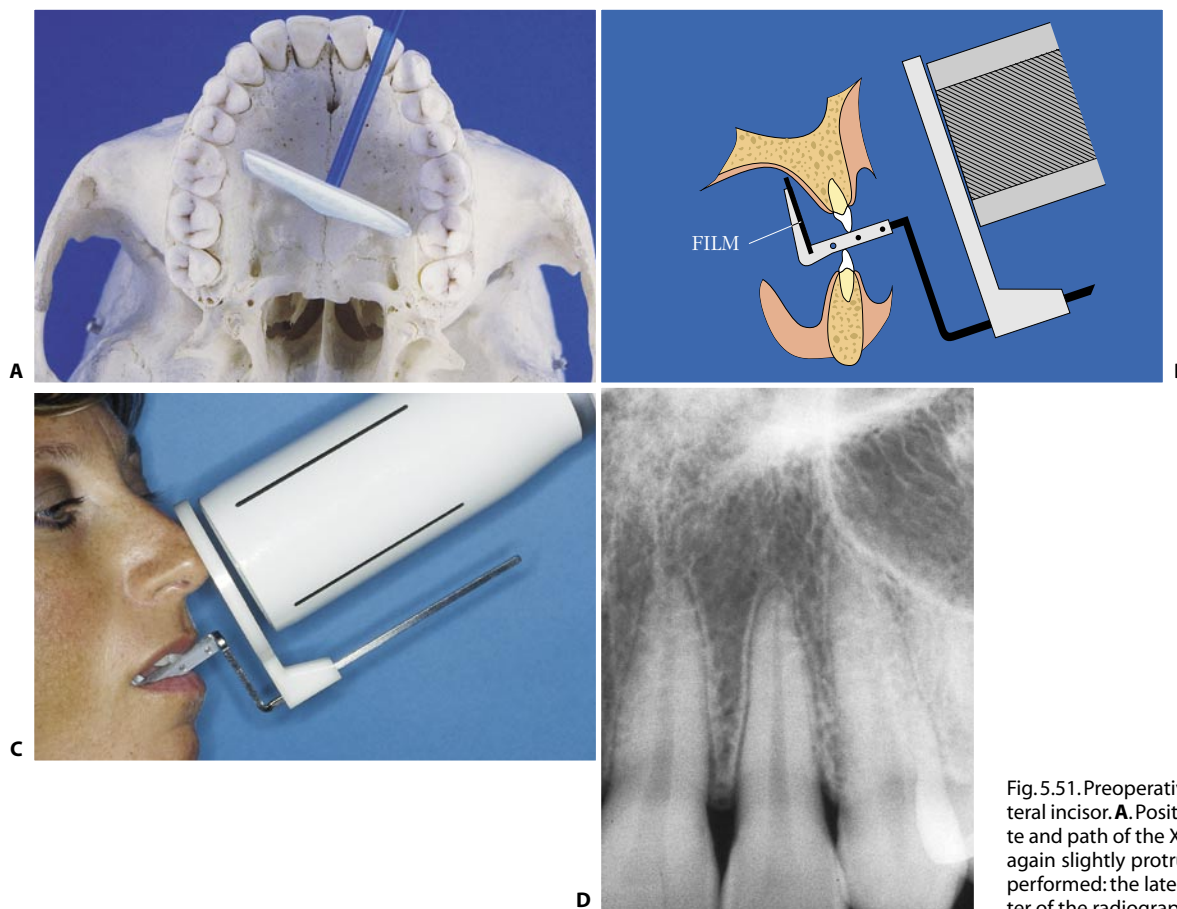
Preoperative radiograph of the upper lateral incisor. A. Positioning of the film on the palate and path of the X-rays. B. The mandible is once again slightly protruded. C. Radiograph correctly performed: the lateral incisor must be in the center of the radiograph.
